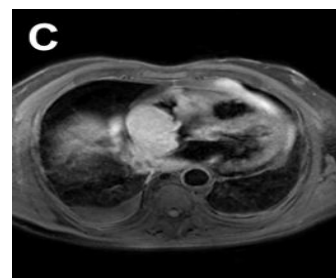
January 2011 - Contrast enhanced MRI images after gadolinium administration: BB T1 sequences showed mild delayed enhancement in the right atrial mass.
